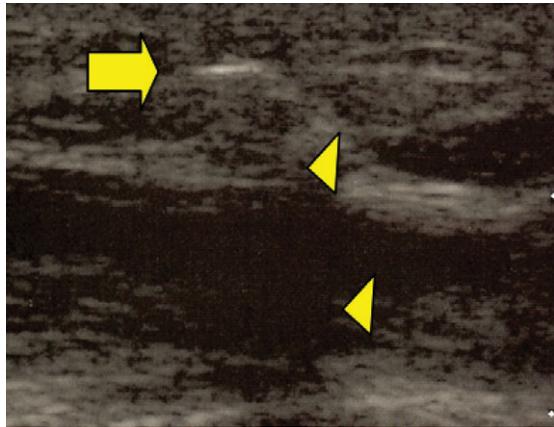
Ultrasound localization of glass foreign body. A fragment of glass is hyperechoic (white) and clearly visible (arrow) in the soft tissue. Due to its dense structure, it creates a reverberation artifact (arrowheads), which is visible below the foreign body. The presence of reverberation artifact aids in confirming that the object visualized is, in fact, a foreign body and not a part of normal anatomy. The other bright white object, seen at the bottom of the image, is the cortex of a bone.
